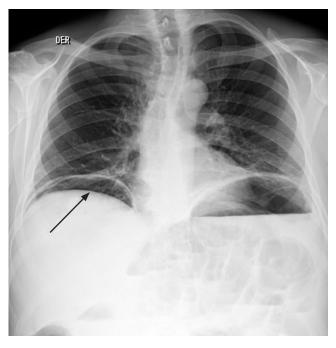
Posteroanterior standing chest x-ray shows bilateral pneumoperitoneum (arrow) with a bilateral basal subpulmonary collection of liquid on the left accompanied by the elevation of both hemidiaphragms and bilateral biliary reticular interstitial opacities without pleural effusion.
